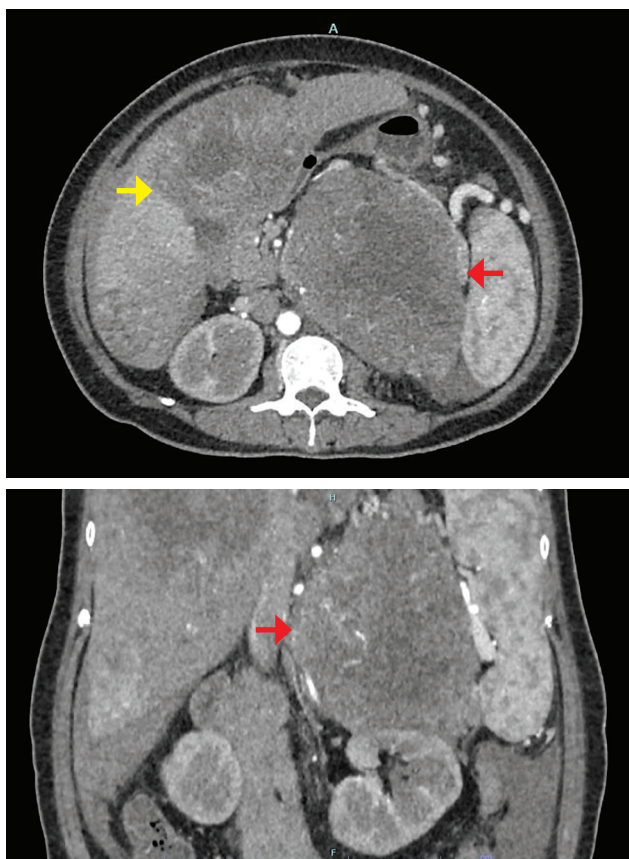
(A) Large heterogenous left adrenal mass (*red arrow*) with central hypodensity and multiple heterogenous masses (*yellow arrow*) in the right liver lobe (CT Abdomen axial view in arterial phase). (B) Left adrenal mass (*red arrow*) displaced the left kidney with no clear fat plane and abuts the spleen (CT abdomen coronal view in arterial phase).
